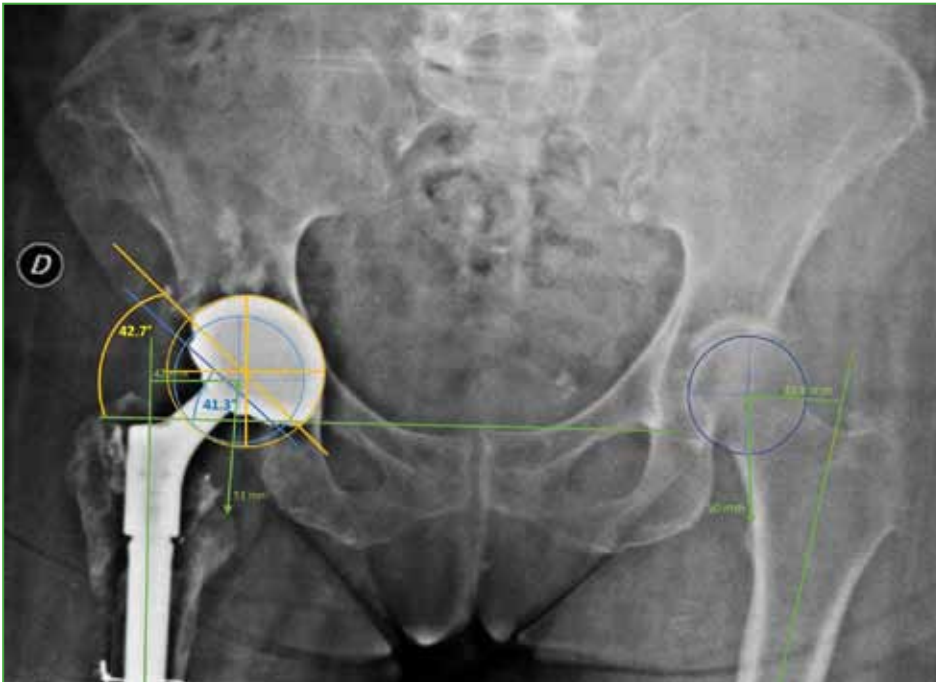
Postoperative radiographic evaluation.
